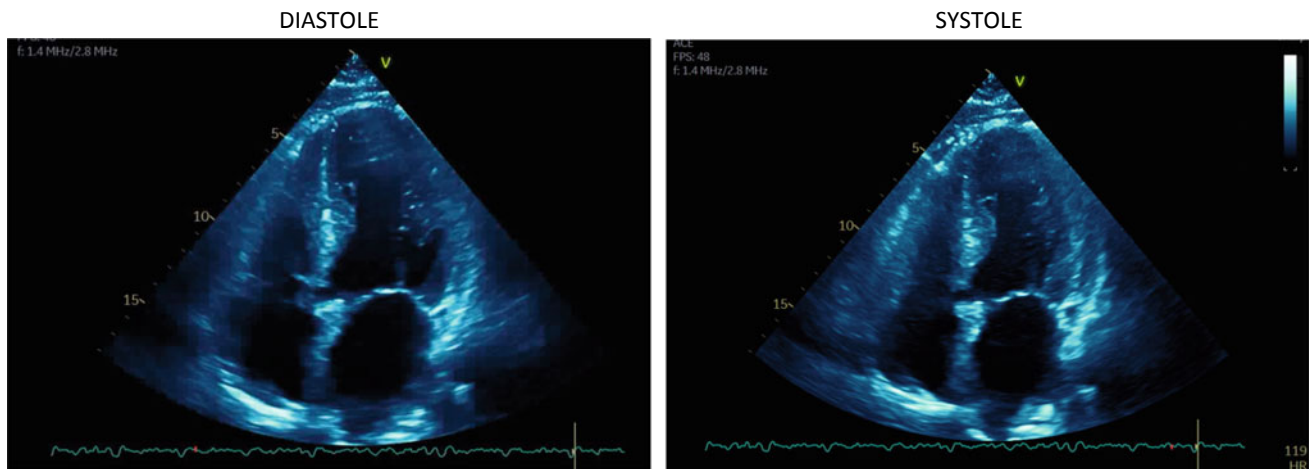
Apical four-Chamber view, August, 2020, Ejection fraction = 30%
